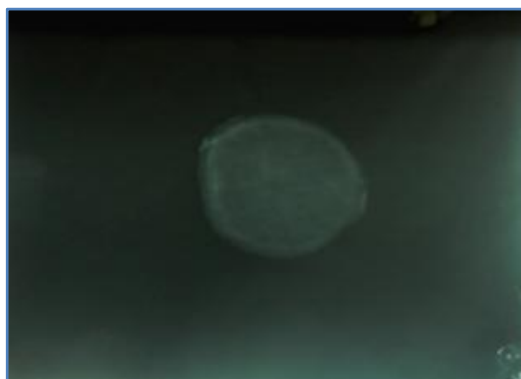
Post-operative radiograph of the vaginal foreign body
